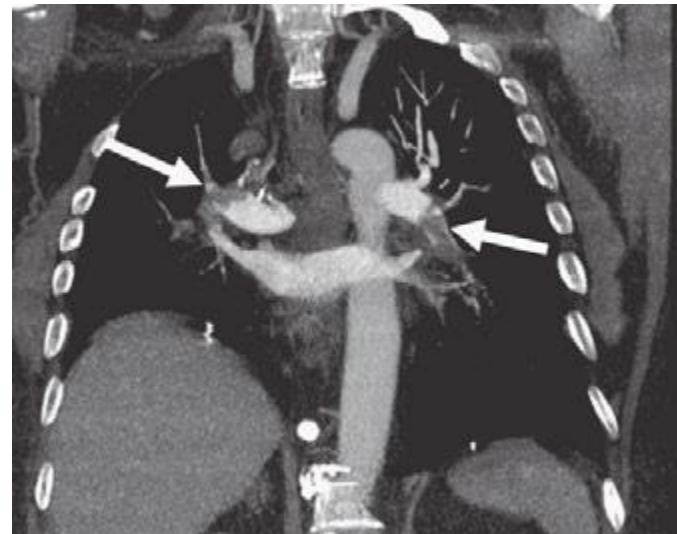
Large bilateral proximal PE on a coronal chest CT image in a 54-year-old man with lung cancer and brain metastases. He had developed sudden onset of chest heaviness and shortness of breath while at home. There are filling defects in the main and segmental pulmonary arteries bilaterally (white arrows). Only the left upper lobe segmental artery is free of thrombus.
